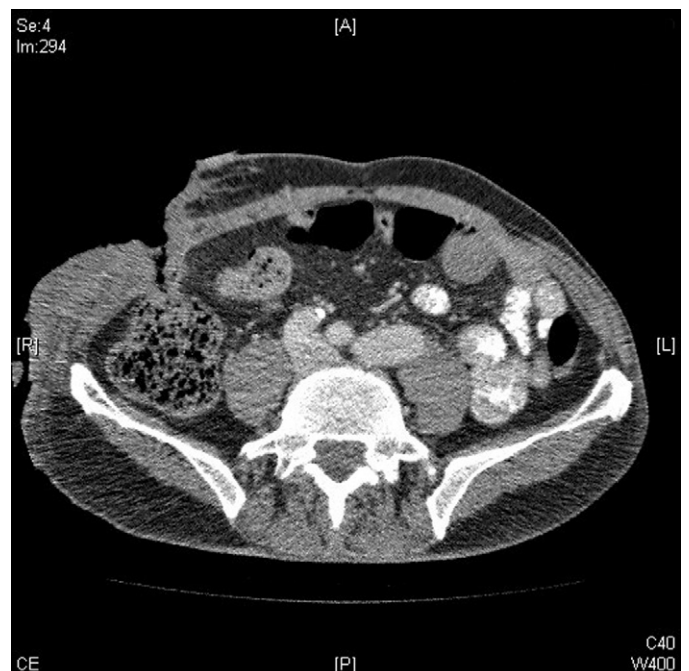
CT slice clearly displaying a fistula between the abdominal wall and caecum.
